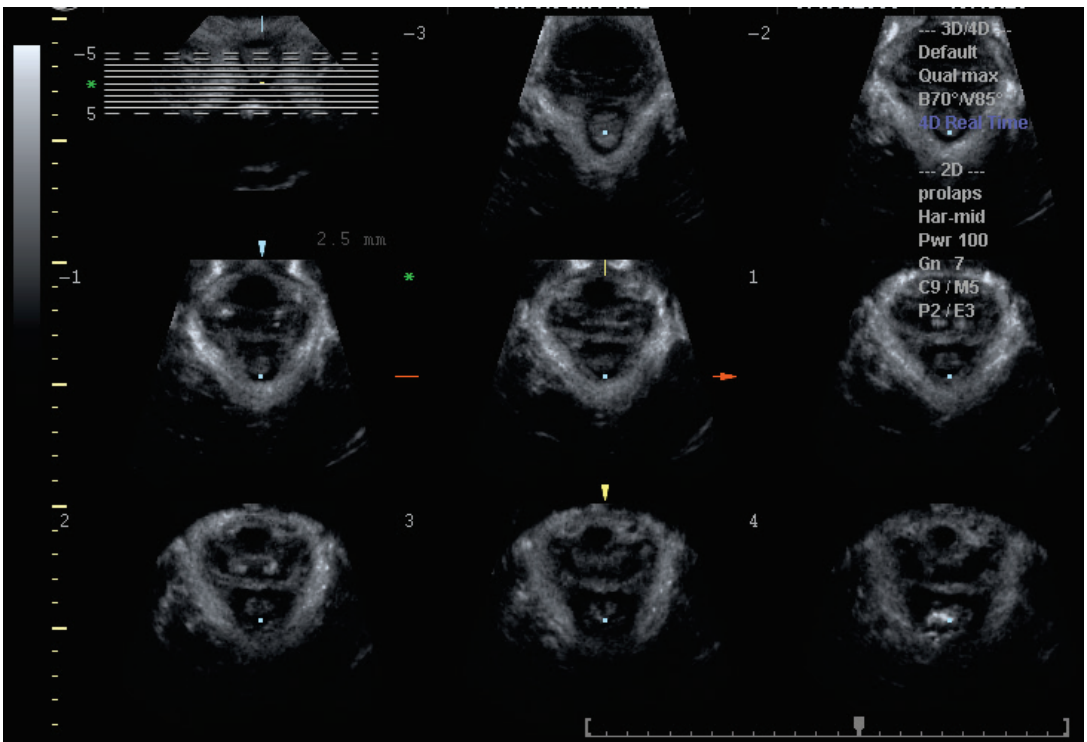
Tomographic ultrasound imaging in oblique axial plane. Normal attachment of the levator ani muscle.
